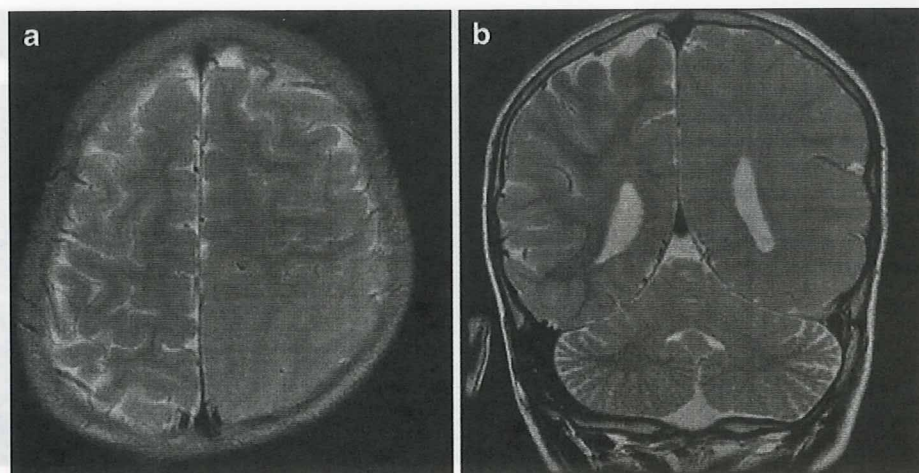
MR images of left localized megalencephaly in a 6-year-old boy with very severe grade 3 seizures and status epilepticus from the age of 3 days. a, b Axial and coronal T2-weighted images show focally enlarged occipital and parietal lobes with ill-defined gray and white matter differentiation (occipital-lobe-dominant type)
